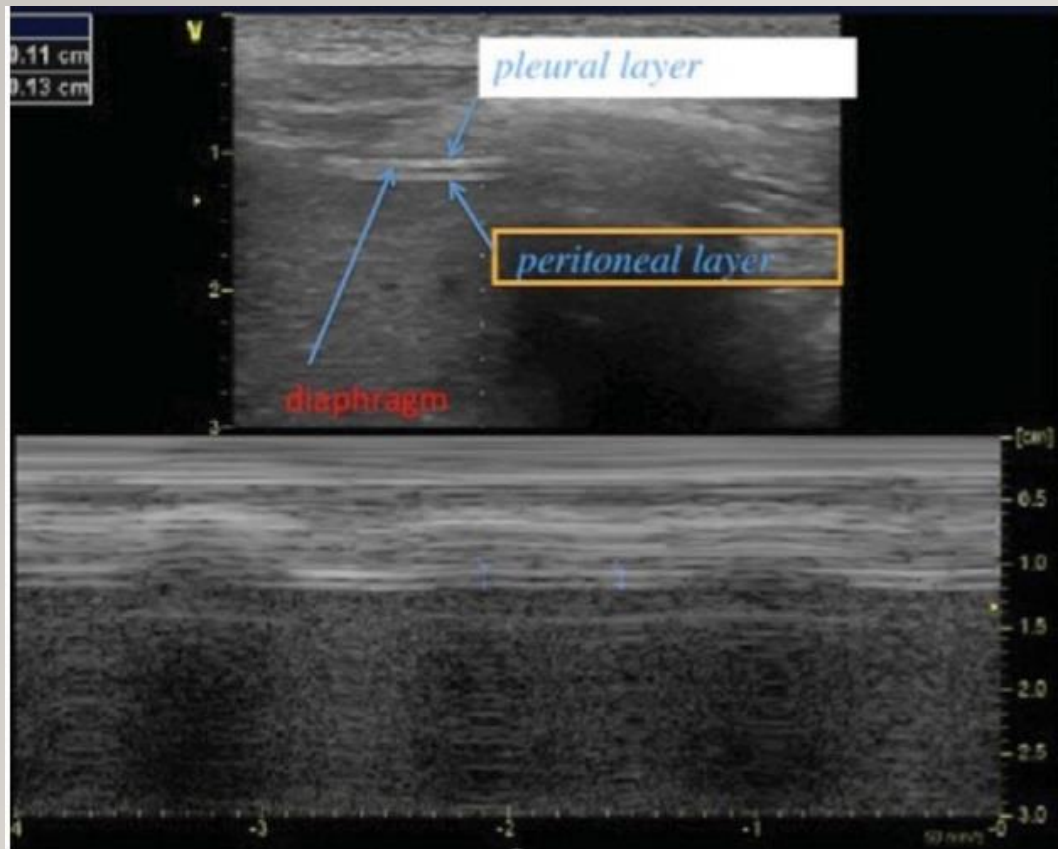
Diaphragmatic contraction in M-mode sonography during a spontaneous breathing trial in a patient suffering from critical illness neuromyopathy (the *scale* at the *bottom* represent time in seconds). Diaphragmatic weakness is evidenced by the very small diaphragmatic displacement (0.5 cm)
